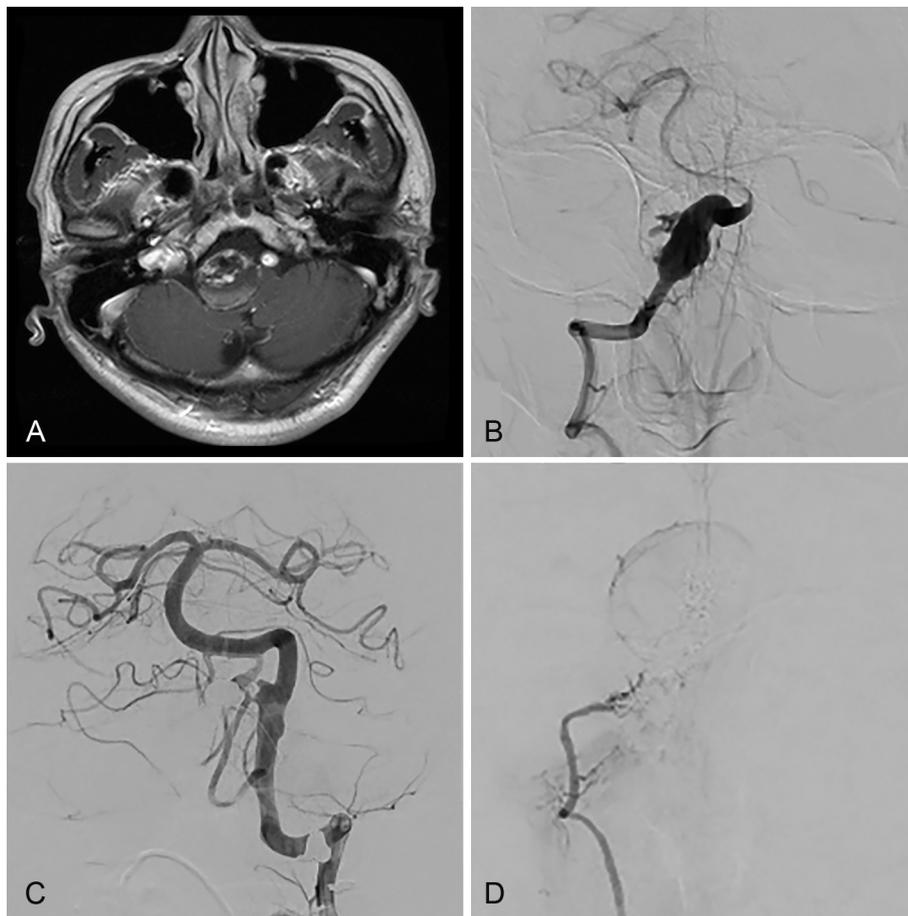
A) Initial enhanced MRI (T1WI sequence) performed at our hospital 1 year after the first coil embolization. B) Right vertebral angiography (VAG) before the first coil embolization (AP view). C) Left VAG just after coil embolization (AP view). D) Right VAG before the first direct surgery (AP view).
